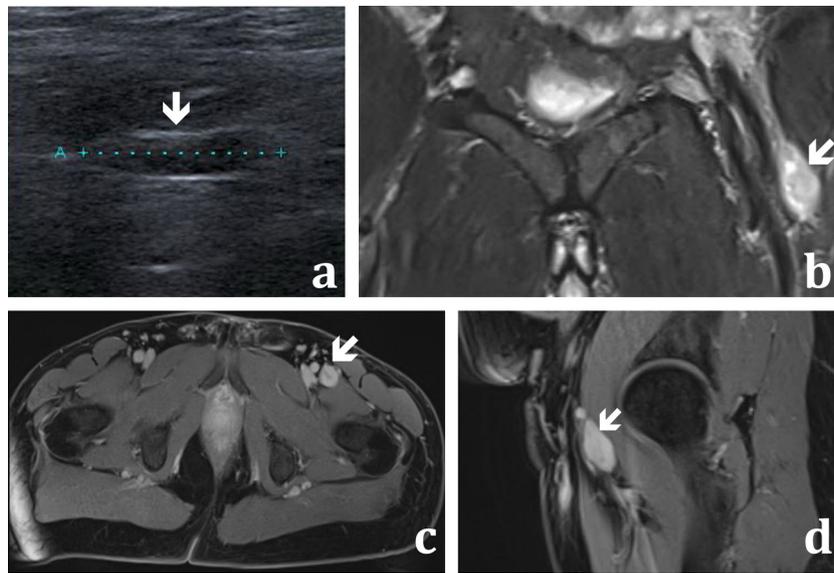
a: ultrasonography view showing a hypoechoic mass in the left inguinal area (); b, c and d: T2W in coronal views and T1 W MRI in axial and sagittal views with gadolinium injection showing a well delimited mass attached on the left femoral nerve ().
